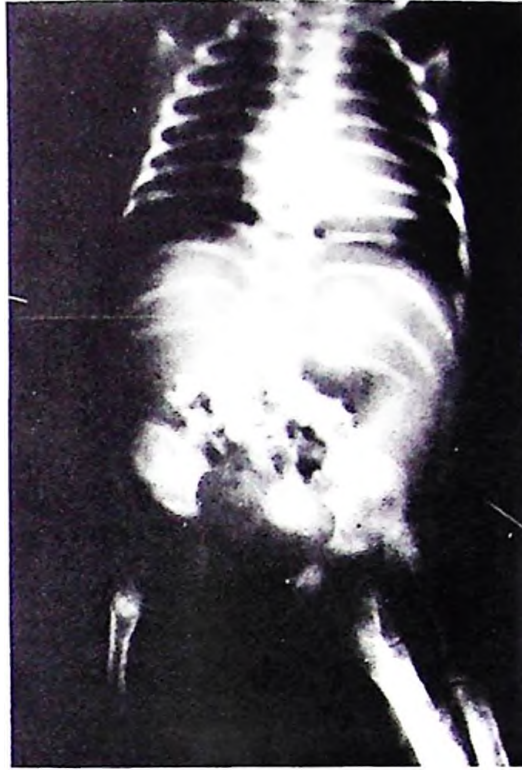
An x-ray of the spine showed a complete split of the lower lumbar spine and absence of sacrum.
